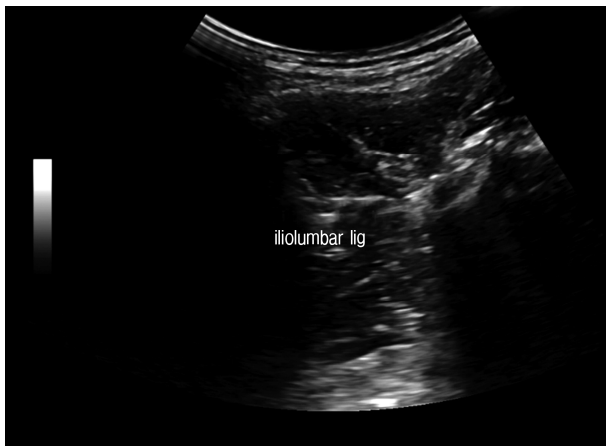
Iliolumbar ligament as target point of prolotherapy on ultrasonography.
